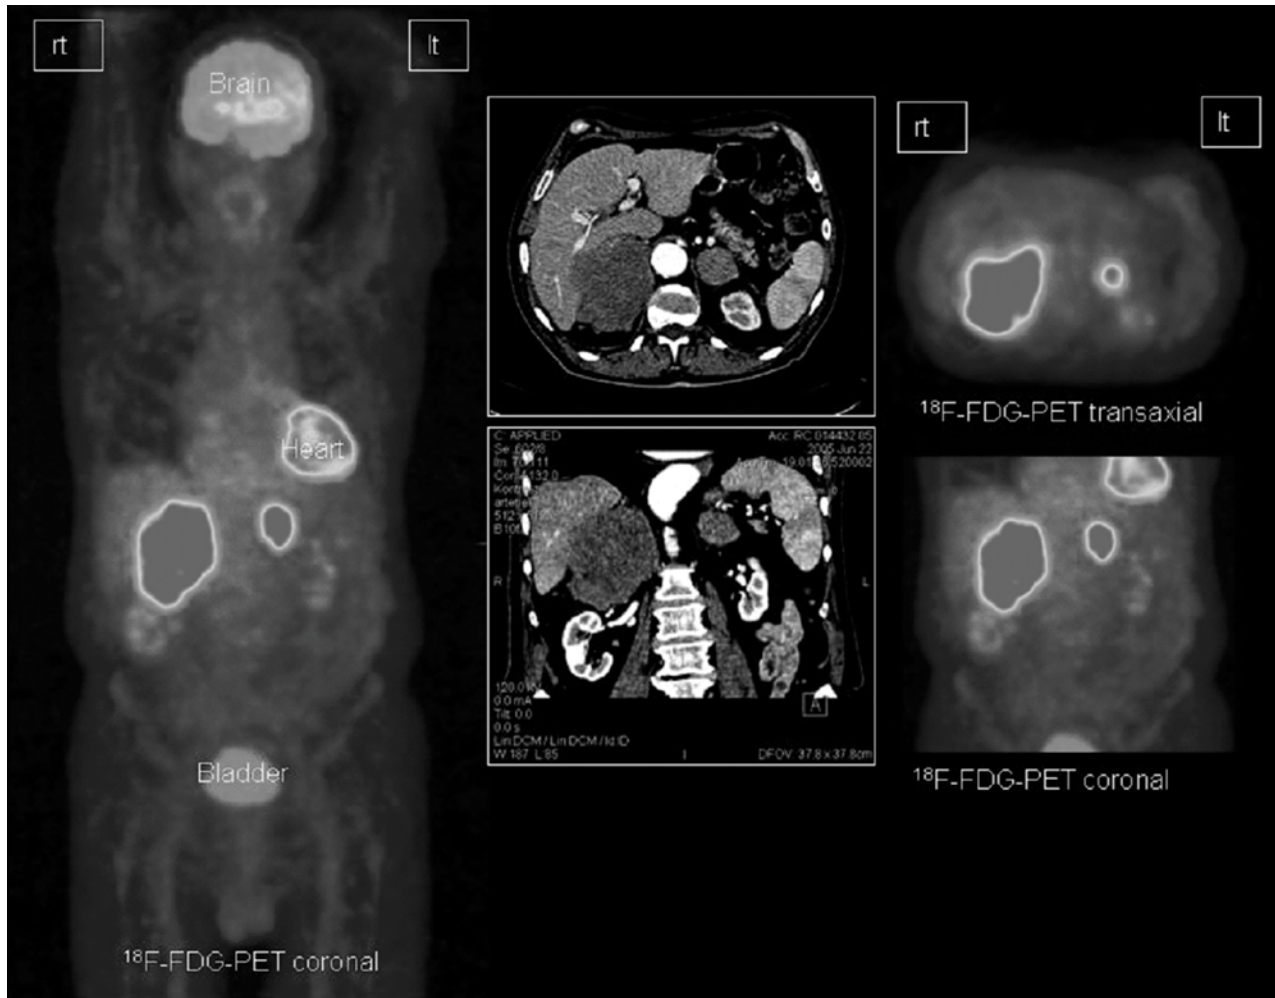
Axial and sagittal PET CT scan. Intense FDG uptake in bilateral adrenal masses. The right adrenal mass is bigger than the left. There are no areas of abnormal FDG uptake.
